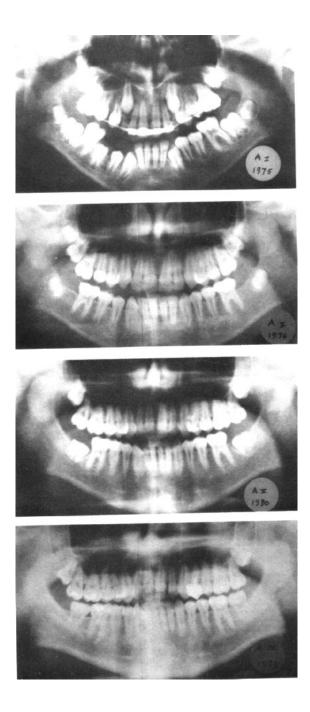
Case B, Class I, boy 11 years old at the time of second molar removal. Final radiograph, age 18.
